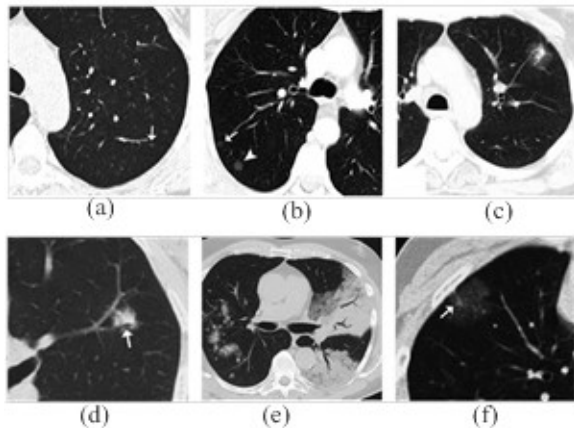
Lung adenocarcinoma [(a): pre-invasive lesions by CT scan; (b): multiple frosted glass nodules of AIS/AAH by CT scan; (c): some solid nodules of infiltrating adenocarcinoma by CT scan; (d): mucinous original adenocarcinoma by CT scan; (e): infiltrating mucinous adenocarcinoma by CT scan; (f): infiltrating non-mucinous adenocarcinoma by CT scan]
